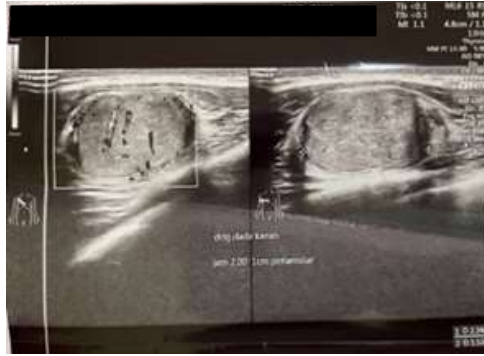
Right breast nodule ultrasonography.
